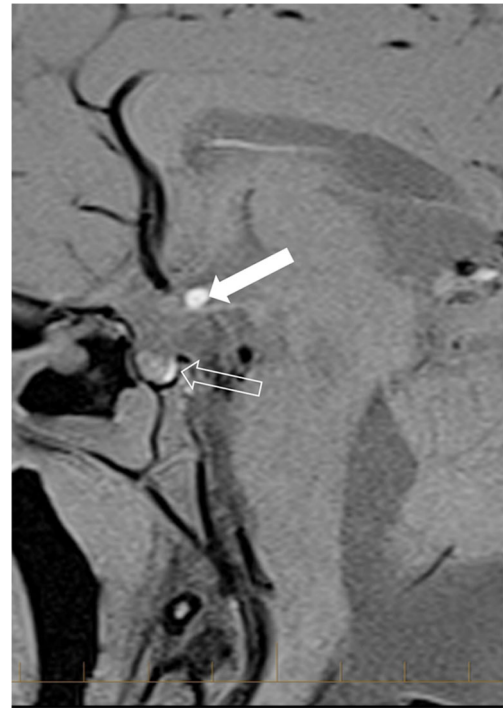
Case 5, a girl age 7 years 4 months. T1-weighted fat-saturated sagittal MR brain midline image shows a second and ectopic T1 bright spot posterior and cranial to the optic chiasm (*solid arrow*). A T1 bright spot also appears in the sella (*open arrow*)
